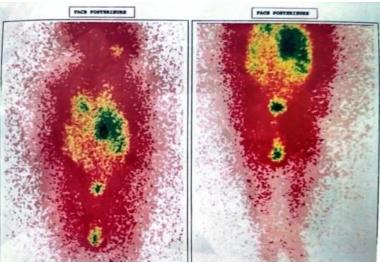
MIBG scintigraphy found the focus of right adrenal hyperfixation, with no other secondary location
